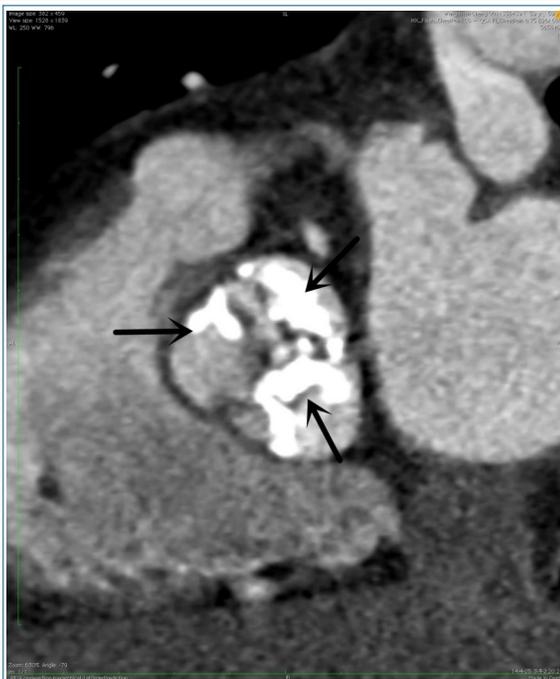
CT Images Showed the Native Calcified Valves (arrow).
